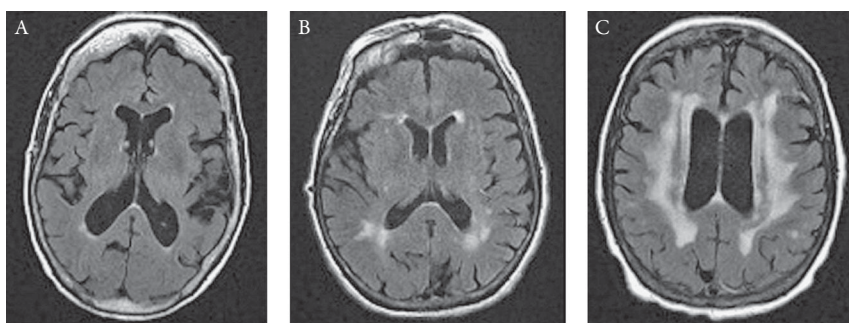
(A–C) Axial fluid-attenuated inversion recovery (FLAIR) images of mild (A), moderate (B), and severe (C) white matter hyperintensity.
